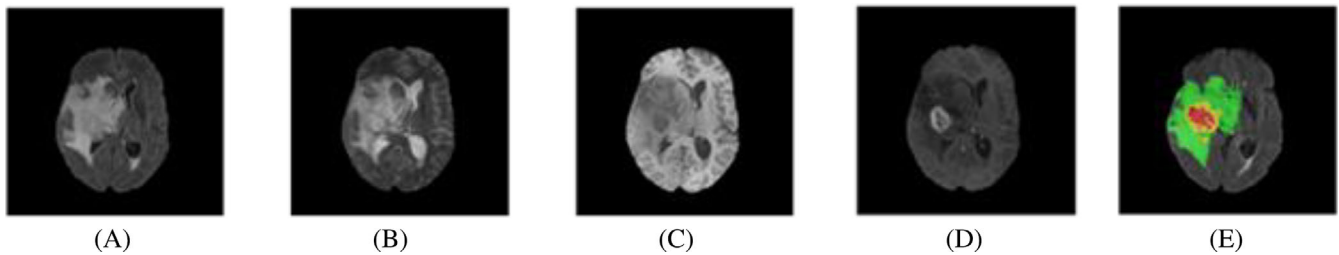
The four MRI modalities were used in this study. (A) shows the Flair image, (B) shows the T2 image, (C) shows the T1 image, (D) shows the T1CE image, and (E) shows the ground-truth mask.
